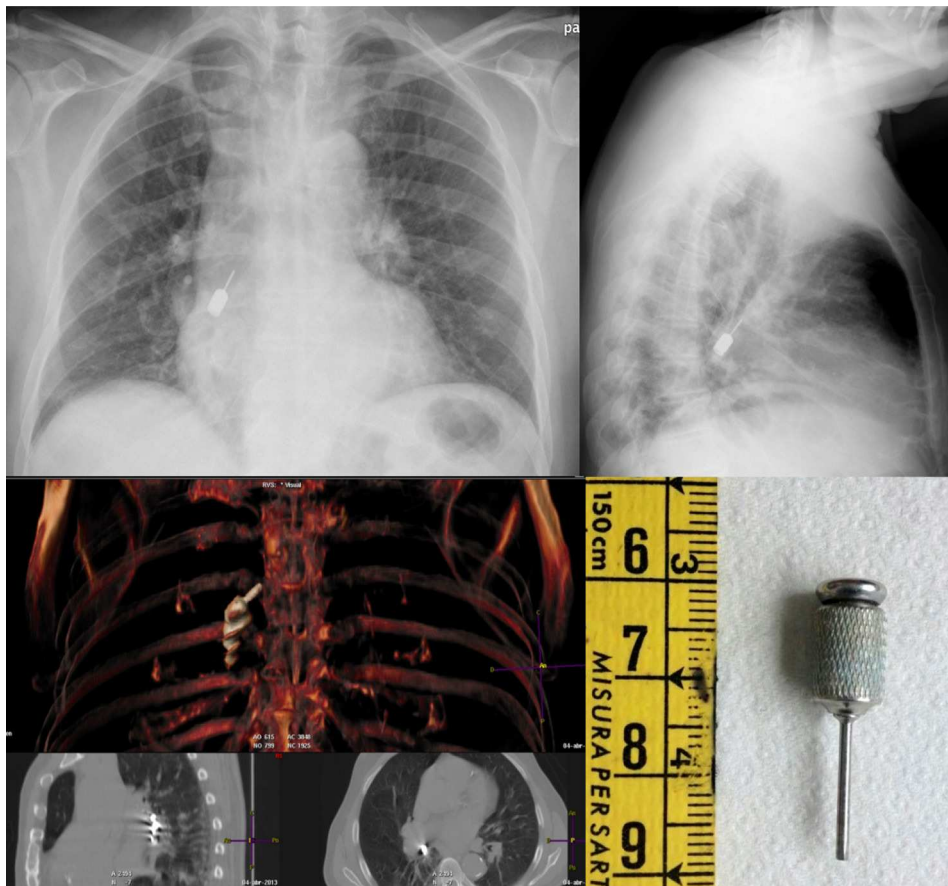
The upper images show the chest X-ray with the drill bit in the bronchus intermedius. In the lower figures, the chest CT can be seen on the left and the foreign body extracted is shown on the right.
